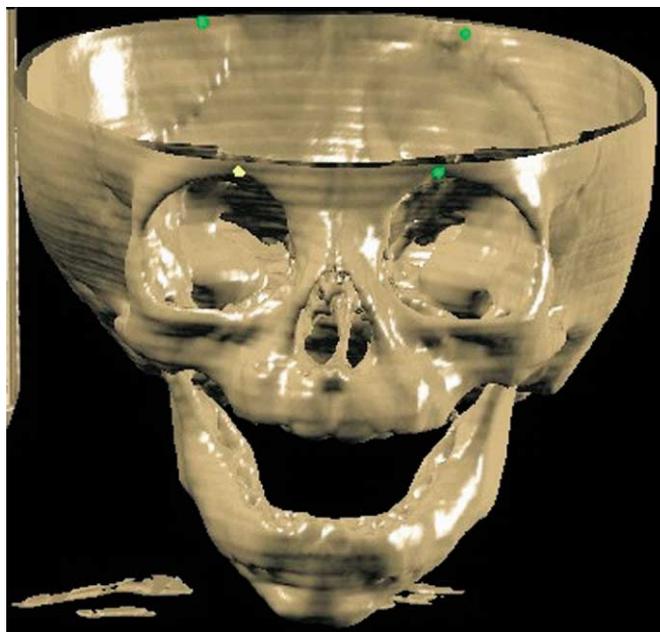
CT reconstructed image measuring the distance between the anterior supraorbital notch and the contralateral occipital bone.
